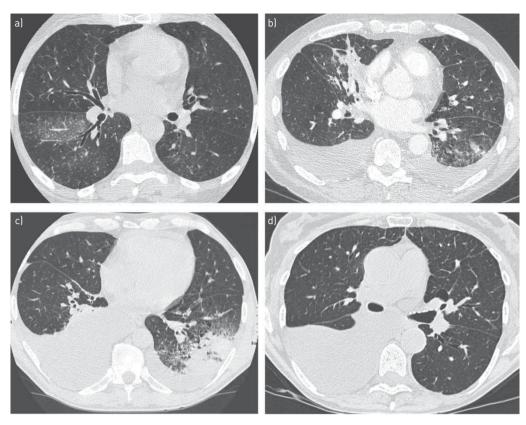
Various chest computed tomography scan patterns of dasatinib-related pleuro-parenchymal complications. (a) ground-glass opacities in the lower right lobe; (b) alveolar consolidation in the middle lobe associated with bilateral pleural effusion; (c) alveolar consolidation in the lower left lobe associated with bilateral pleural effusion; (d) right-sided pleural effusion.
